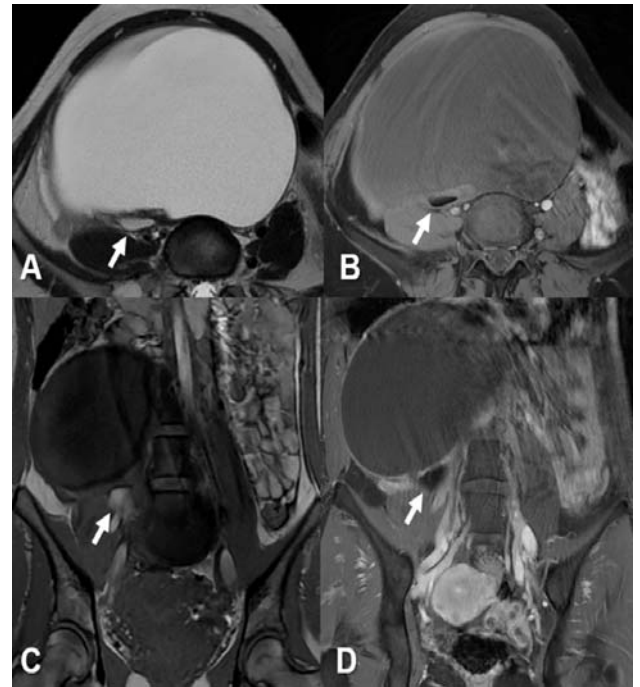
Axial T2, axial T1 fat-suppressed, coronal T1, and post-contrast T1 fat-suppressed MRI images demonstrate a small layering fat component (arrow) located inferior and posterior to the large cystic lesion. The fat shows hyperintense signal on T2 and T1 (a and c) with signal drop-out on fat-suppressed images (b and d).
